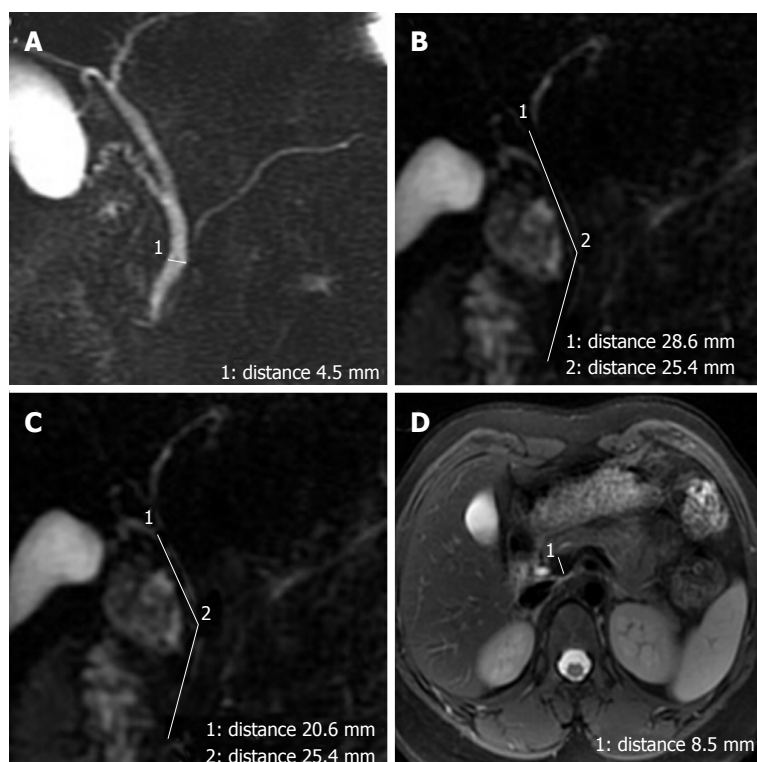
The measurement method. A: Measurement of the common bile duct (CBD) diameter by placing an electronic caliper at the widest visible portion of the CBD on magnetic resonance cholangiopancreatography (MRCP); B: Measurement of the length of the extrahepatic bile duct on MRCP. It is the sum of the length from the hepatic hilum to the tortuous portion and from the tortuous portion to the ampulla; C: Measurement of the length of the CBD on MRCP. It is the sum of the length from the cystic duct insertion to the tortuous portion and from the tortuous portion to the ampulla; D: Measurement of the portal vein anteroposterior diameters by placing the electronic caliper at the splenic veins into the portal vein on T2-weighted images.
